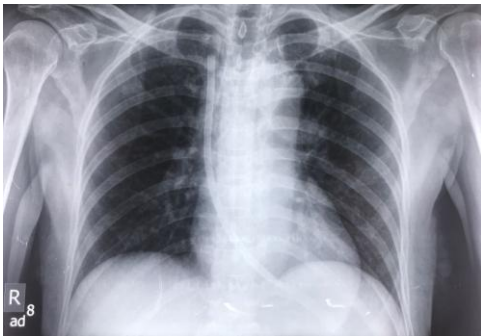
Chest radiograph before surgery
